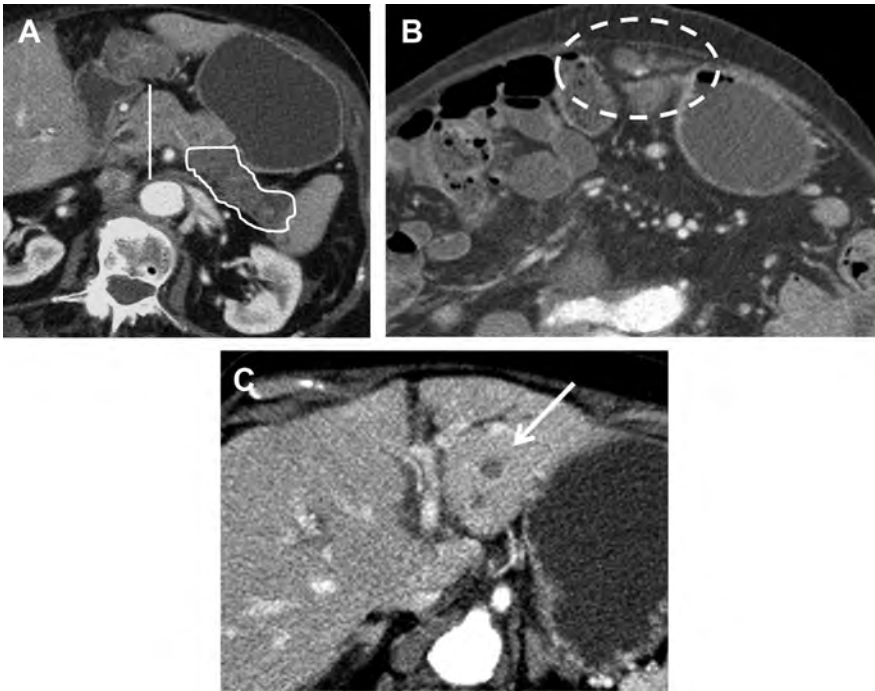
In an 80-year-old woman with diarrhea, contrast-enhanced CT scan (A) shows a pancreatic body/tail hypoenhancing mass (left of SMV, vertical line; outline) (B). There is peritoneal carcinomatosis (dashed circle) and (C) liver metastasis (arrow). This case was non-resectable. With such a presentation, dual-phase CT is not needed.
